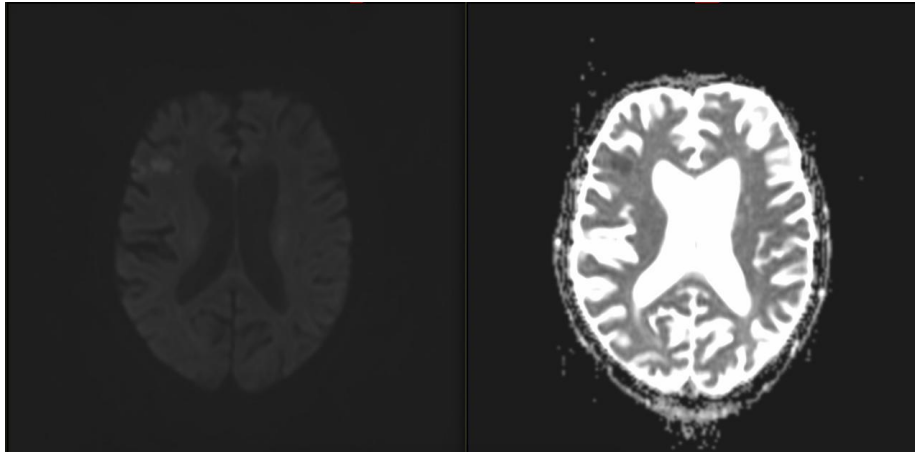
DWI and ADC image shows significant diffusion restriction of the lesion in right frontal sub cortical white matter
